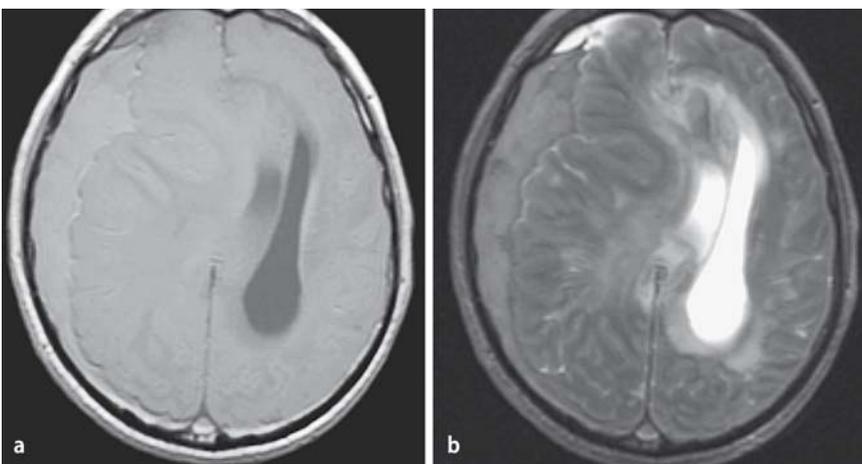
▲ Cranial MRI of an accident victim using T1 (a) and T2 (b) weighted imaging. Extensive subdural hematoma on the right with shifting of the midline structures and compression of the right lateral ventricle
